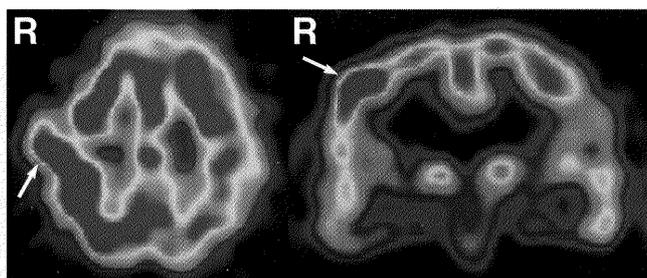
Single photon emission computed tomography scans revealing the same pattern (arrow) as normal brain tissue.
